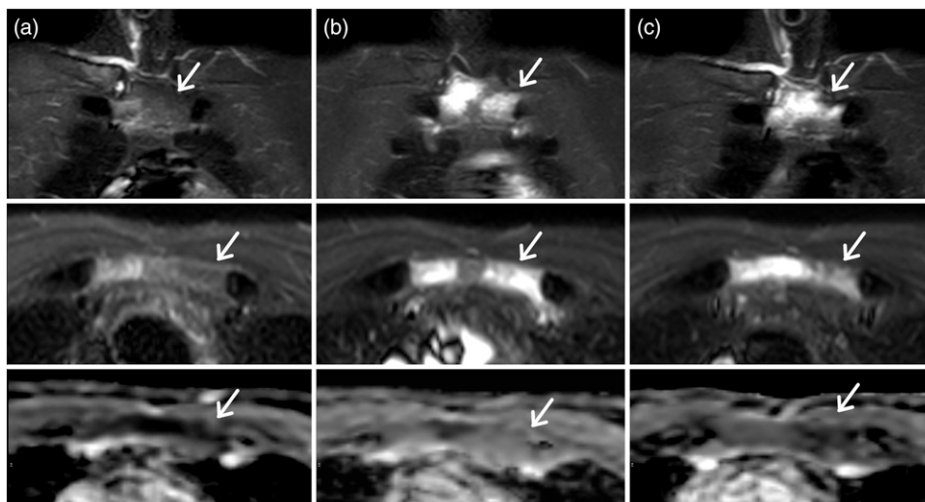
A 61-year-old male with chronic non-bacterial osteitis. MRI images before (a), after 12 weeks (b), and 36 weeks (c) of pamidronate therapy. Coronal STIR images (upper row), axial STIR images (middle row), and axial apparent diffusion coefficient (ADC) maps (lower row) are presented. Compared to baseline (a), an additional lesion in left manubrium (arrow) at week 12 (b) and 36 (c) is visualized.
